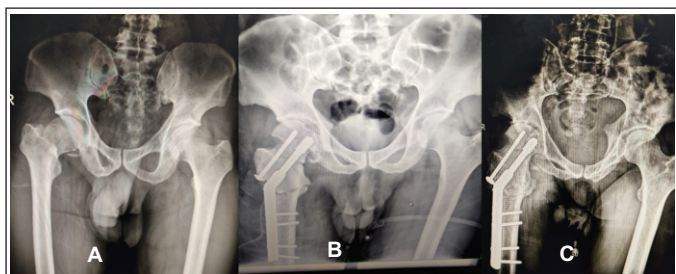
A. Pre op X-ray of pelvis with right sided neck of femur fracture. B. immediate post op X-ray and C. Follow up X-ray showing healing of osteotomy and fracture site.
